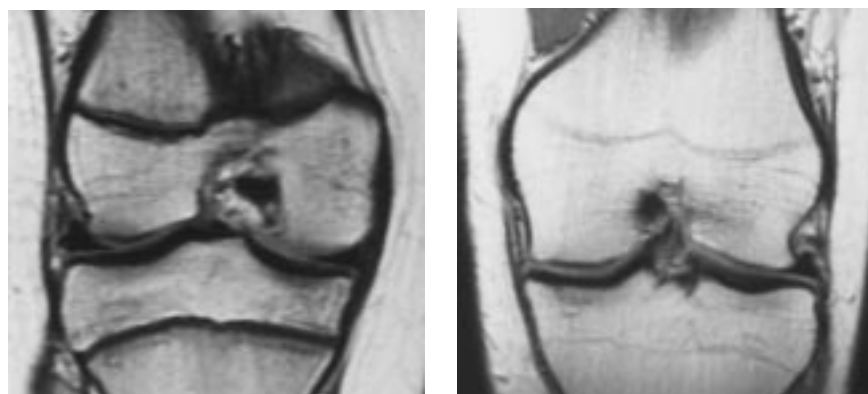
Magnetic resonance images used to evaluate tibial and femoral physal closure. A, Immature subject. B, Mature subject.
